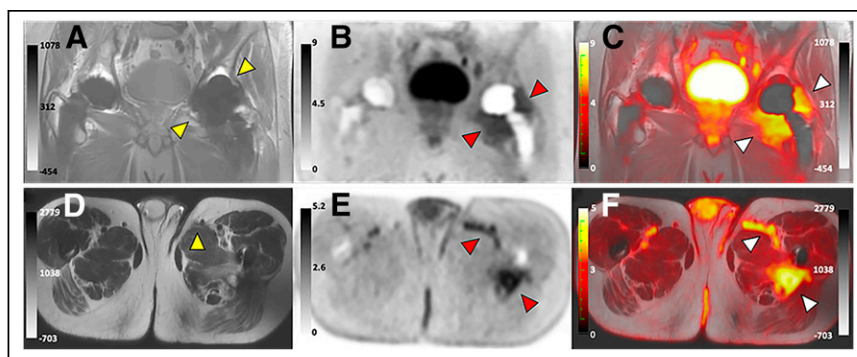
D*-methyl- ^{11}C methionine PET/MR images of 61-y-old man with bilateral hip prostheses and confirmed *C. acnes* infection of left hip. Left bar represents SUV color scale, and right bar represents MRI color scale. (A, B, and C) Coronal MR, PET, and PET/MR images, respectively. Arrows indicate infected joint in A and area of radiotracer uptake surrounding joint in B and C. (D–F) Axial MR, PET, and PET/MR images. Arrows depict sinus tract communicating with skin in D and regions of radiotracer uptake in E and F. (Adapted from (35).)
